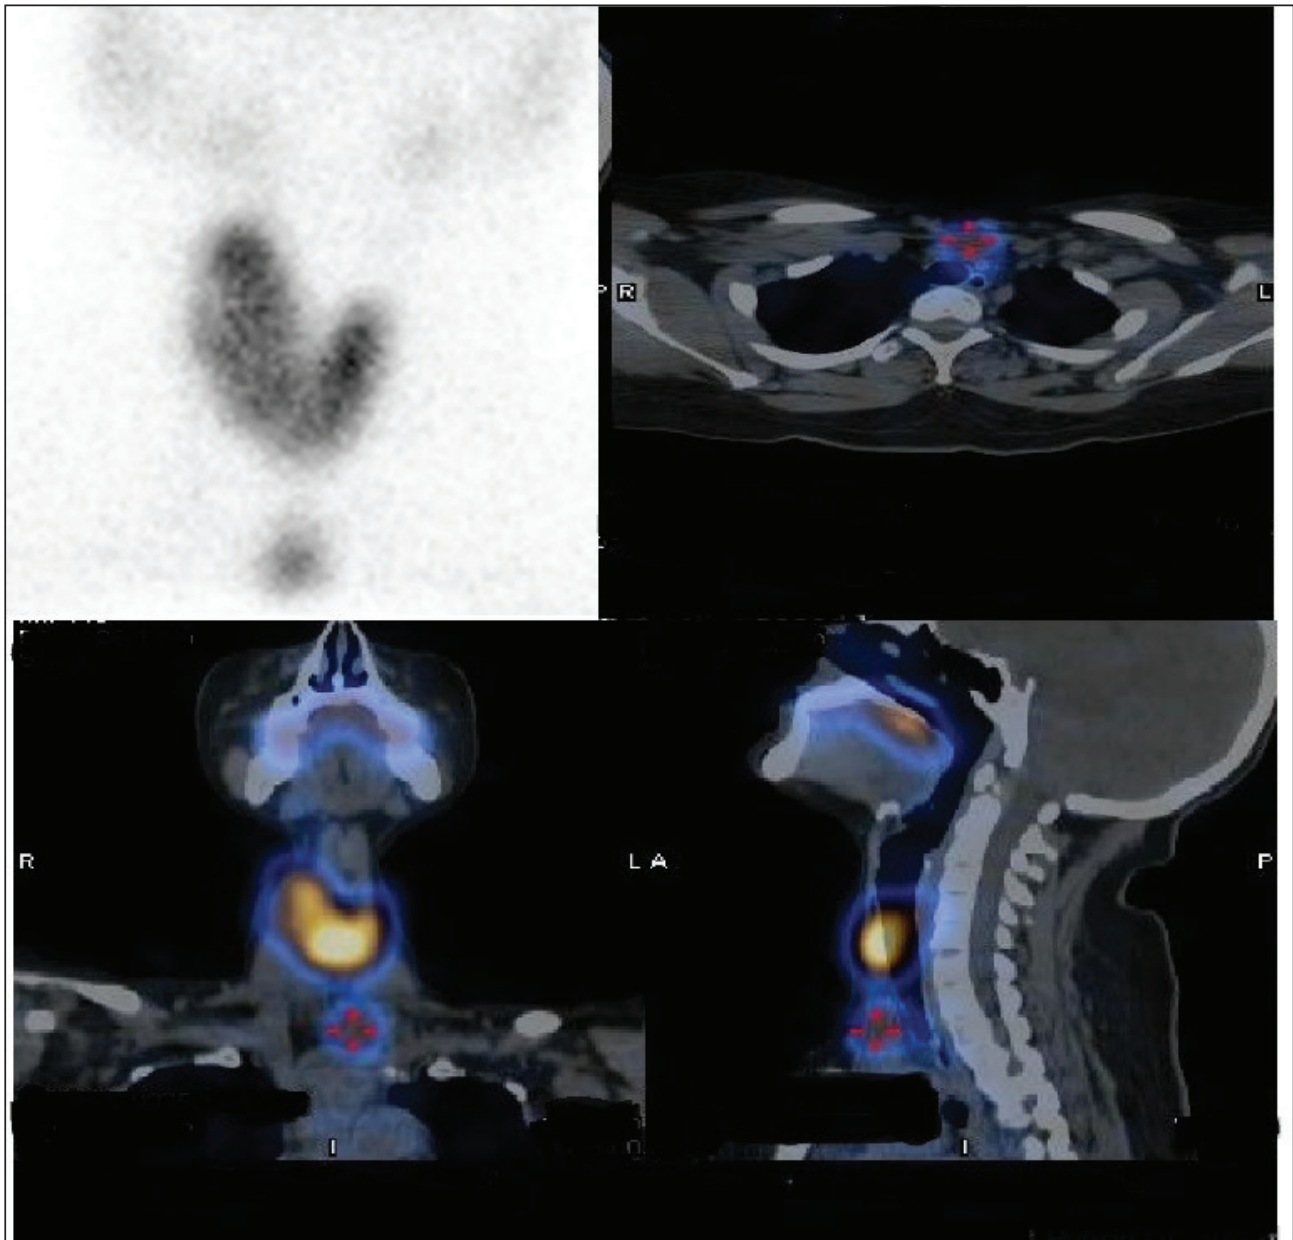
Thyroid scan and SPECT/CT reveal ETT in the superior mediastinum.
